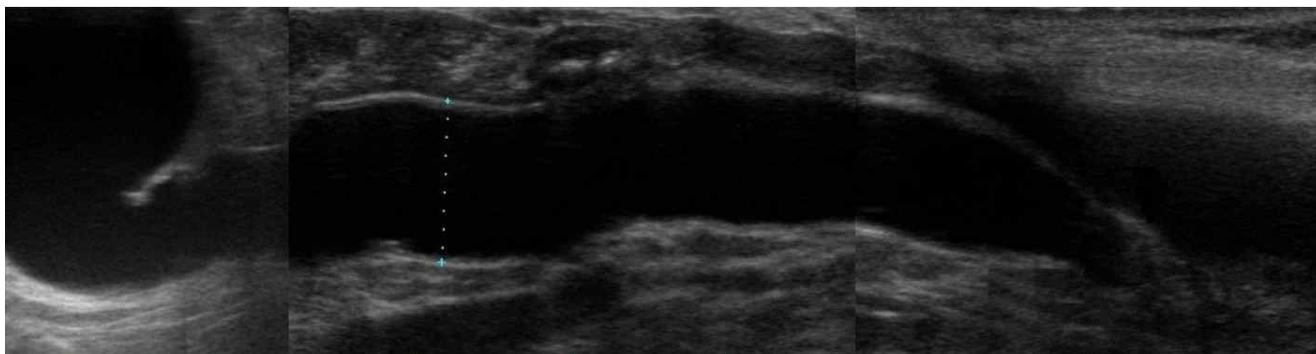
Serial ultrasonographic images of the right kidney and ureter. The hydronephrosis and ureteral dilation with obstructive uropathy were caused by constriction of the distal ureter.
